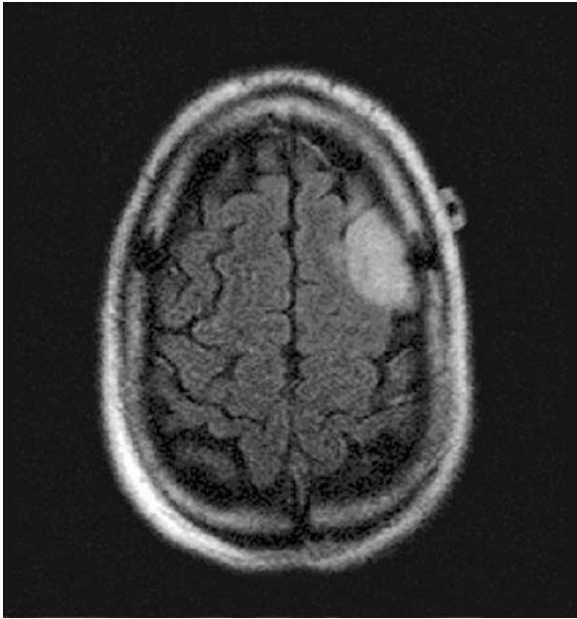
Preoperative axial turbo fluid-attenuated inversion recovery (FLAIR) MRI scan demonstrating an area of increased signal in the left frontal lobe directly below the coronal suture consistent with a low grade glioma. There is an MRI-visible marker attached to the scalp in order to localize the craniotomy flap preoperatively and delimit the size of the cranial opening and operative field
